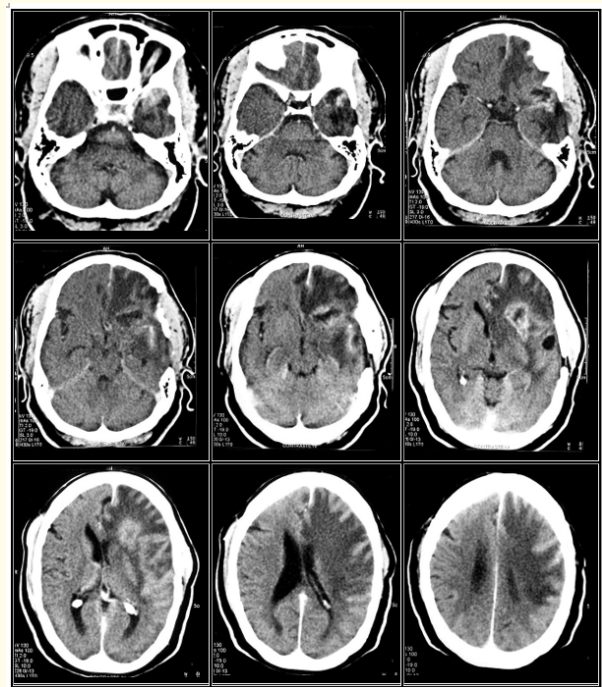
Skull CT image with contrast, axial cut [17].
